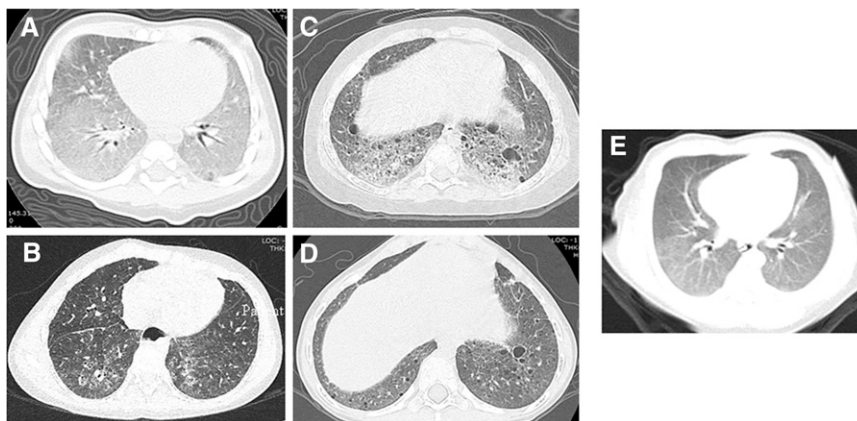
Initial and most recent computed tomography (CT) scan for each patient. (A) Patient 1 initial CT scan with diffuse ground-glass opacities and septal thickening. (B) Patient 1 recent CT scan with nonspecific interstitial pneumonia findings, diffuse ground-glass opacities, and bronchiectasis. (C) Patient 2 initial CT scan with marked interstitial prominence, cystic change, and interstitial/alveolar infiltrate. (D) Patient 2 recent CT scan with interstitial prominence and increased number of parenchymal and subpleural cysts. (E) Patient 3 only CT scan with diffuse ground-glass opacities.
